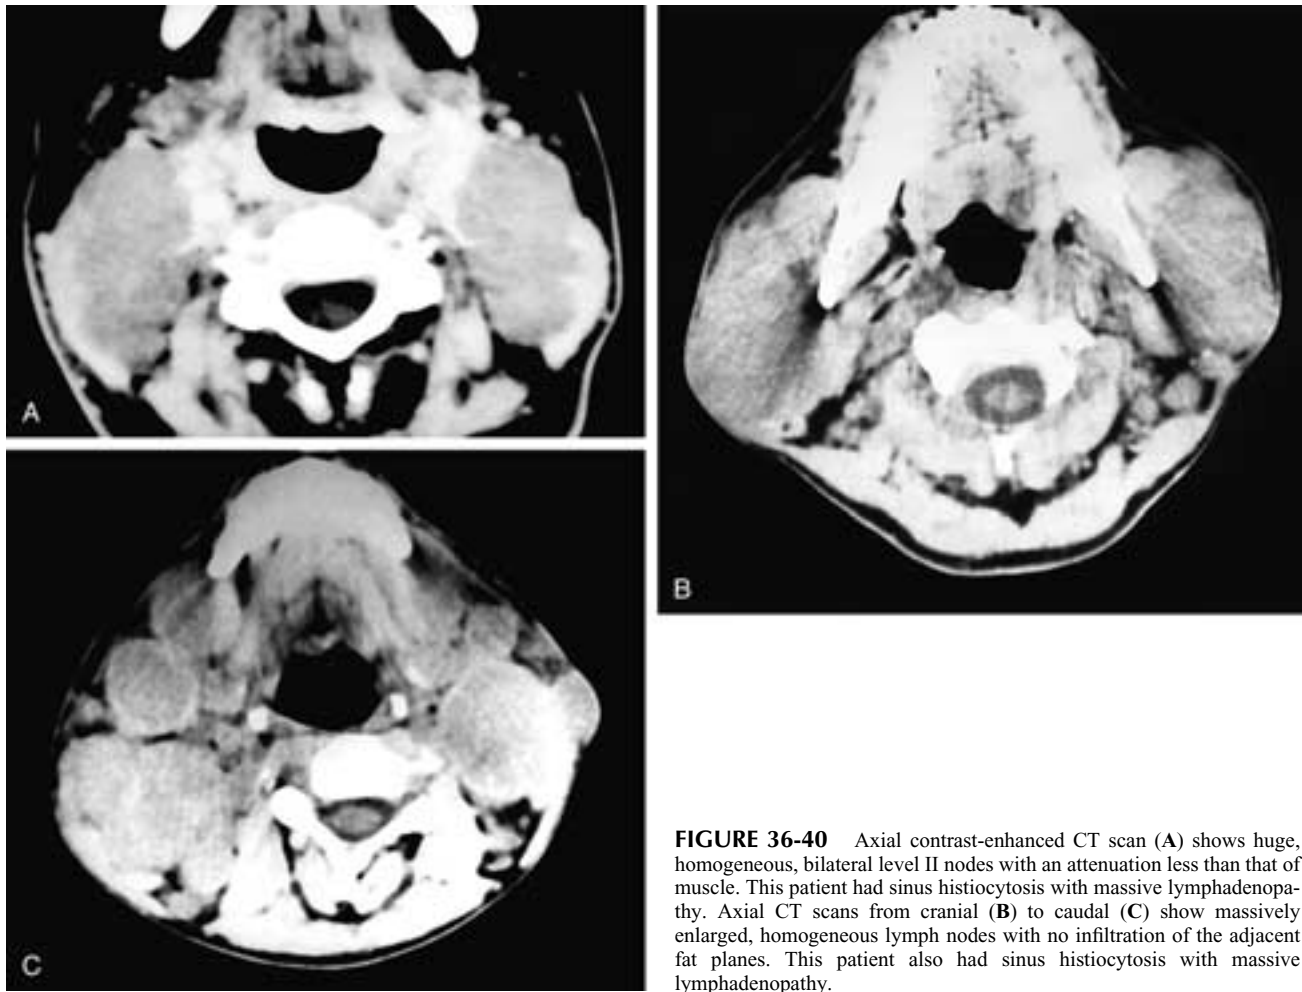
Axial contrast-enhanced CT scan (A) shows huge, homogeneous, bilateral level II nodes with an attenuation less than that of muscle. This patient had sinus histiocytosis with massive lymphadenopathy. Axial CT scans from cranial (B) to caudal (C) show massively enlarged, homogeneous lymph nodes with no infiltration of the adjacent fat planes. This patient also had sinus histiocytosis with massive lymphadenopathy.
